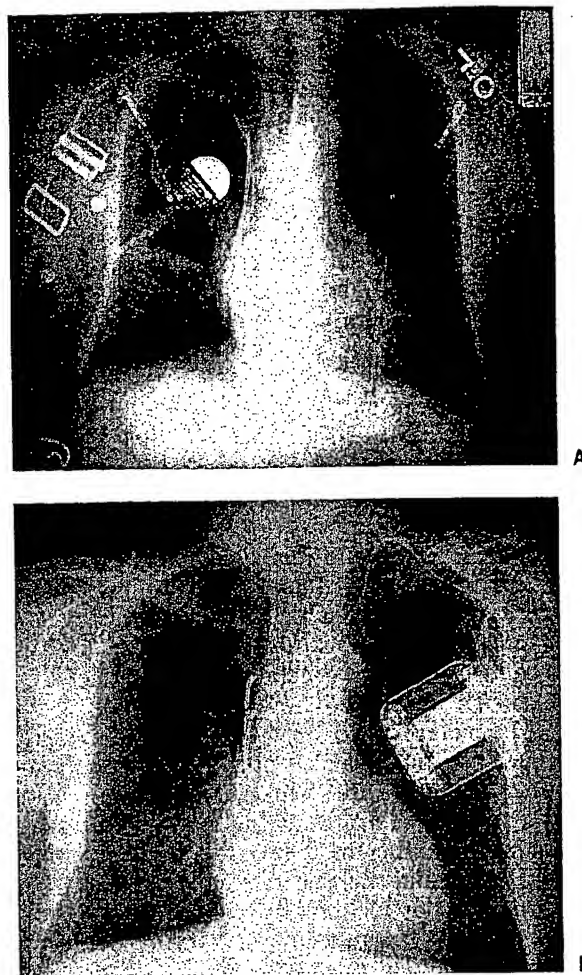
Chest radiograph of a patient prior to (Panel A) and after (Panel B) dual chamber ICD upgrade. This patient had a preexisting right pectoral dual chamber pacemaker with a right abdominal defibrillator, neither of which could be used for the upgrade. The postimplant radiograph shows the new dual chamber ICD and leads in the left pectoral location after successful extraction of the chronic pacing and defibrillating leads.
